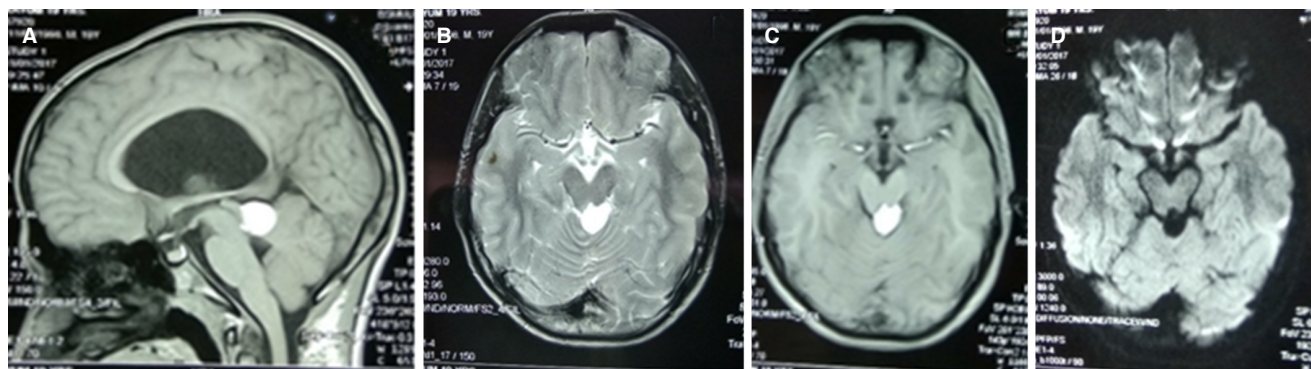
Magnetic resonance imaging of the brain: (A) sagittal T1-weighted (T1-W) sequence showing hyperintense mass over quadrigeminal plate; (B) axial T2-W sequence with hyperintense mass; (C) axial T1-W sequence with contrast showing no contrast enhancement of the lesion; (D) axial DWI sequence showing no restriction of diffusion by the mass. DWI: diffusion weighted image
